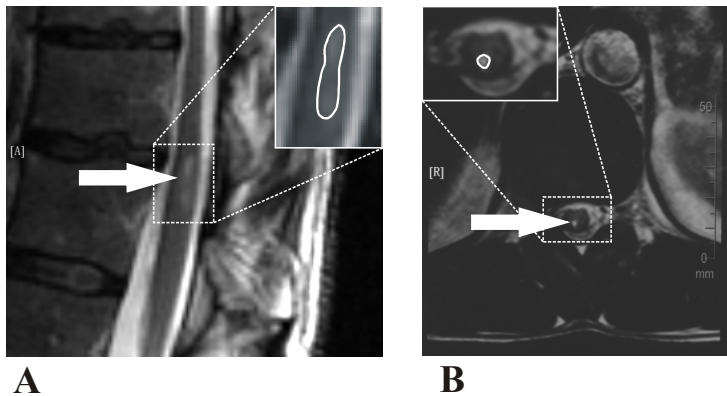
MR images of the patient R.A.'s spinal cord lesion. The dotted square surrounds the lesion that is magnified and marked in the solid line square.
